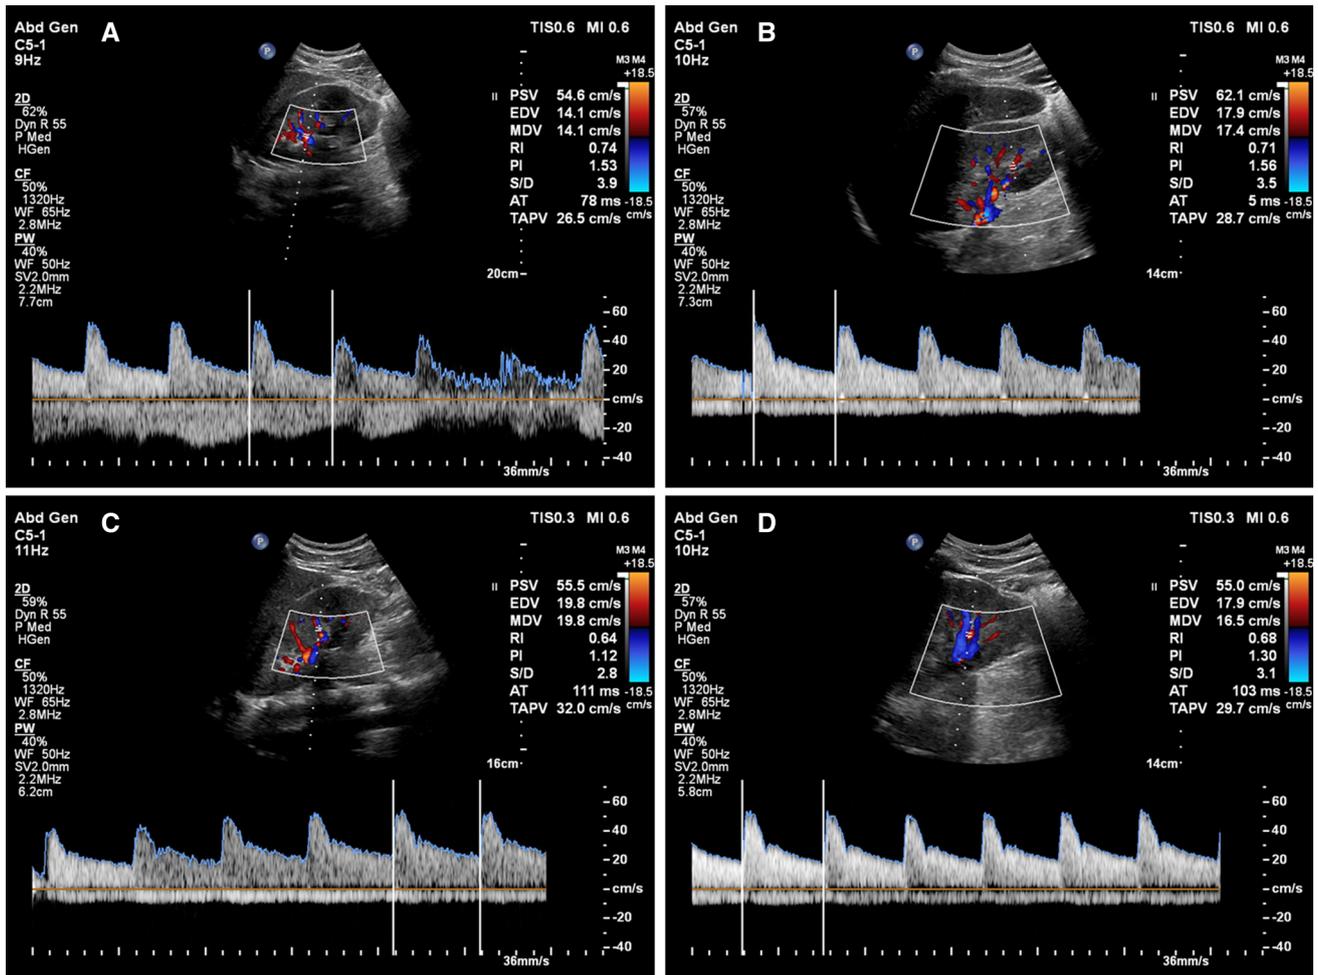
In healthy control, renal resistive index (RRI) is measured by Doppler sonography in a right kidney intrarenal or intralobar artery and is the difference between the peak systolic (PSV) and end-diastolic (EDV) blood velocities divided by the peak systolic velocity (PSV)
